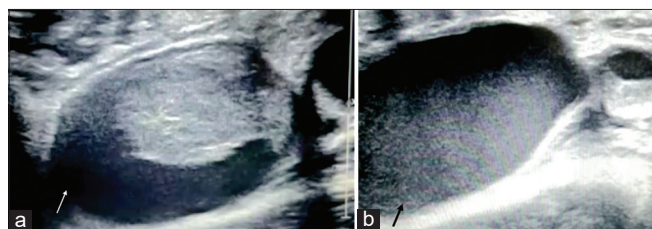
Ultrasound scan of neck: multiple cervical lymph nodes of varying sizes with some showing necrosis (arrow in a and b).
